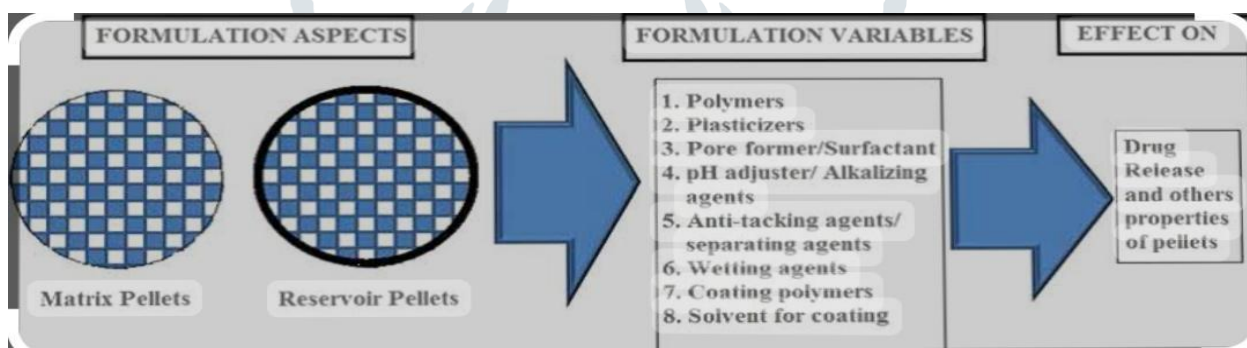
FORMULATION ASPECTS OF PELLETS
